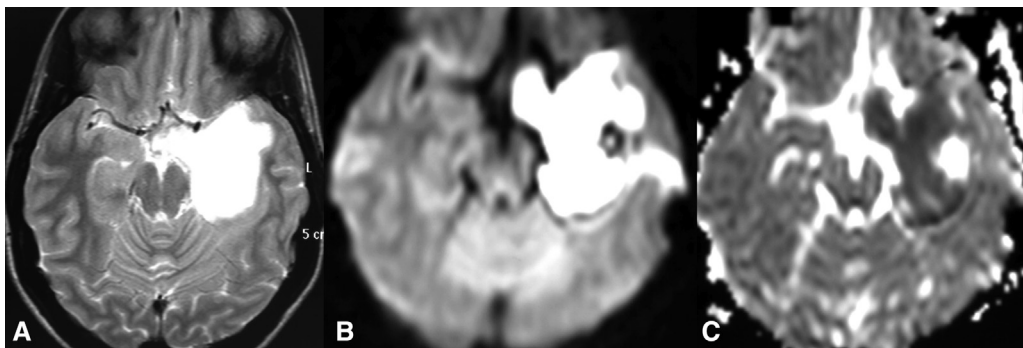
Epidermoid cyst. Axial T2-weighted image (A) shows an extra-axial CSF-like mass compressing left mesial temporal lobe. Diffusion-weighted imaging (DWI) (B) and apparent diffusion coefficient (ADC) map (C) show restricted diffusion.
